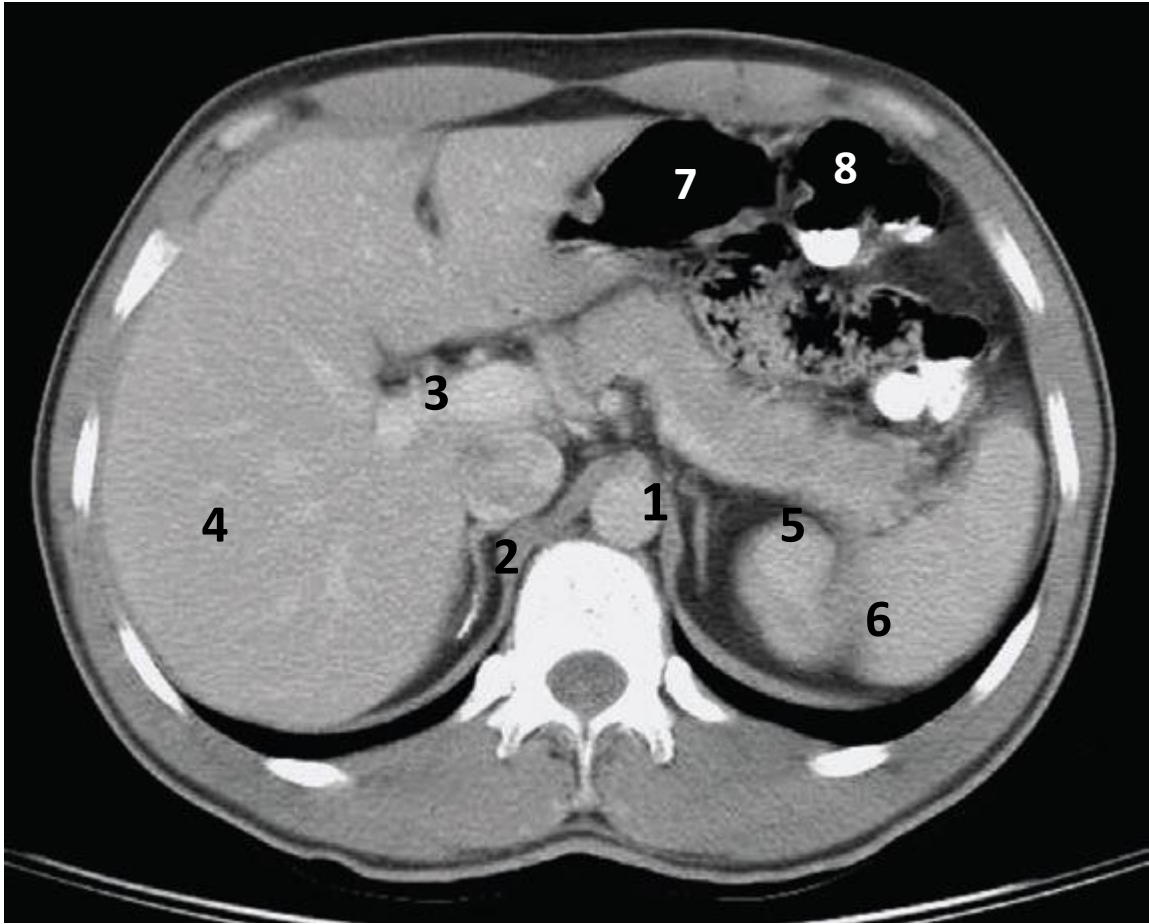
CT crossectional abdominal image (Iannaccone R et.al 2007).
